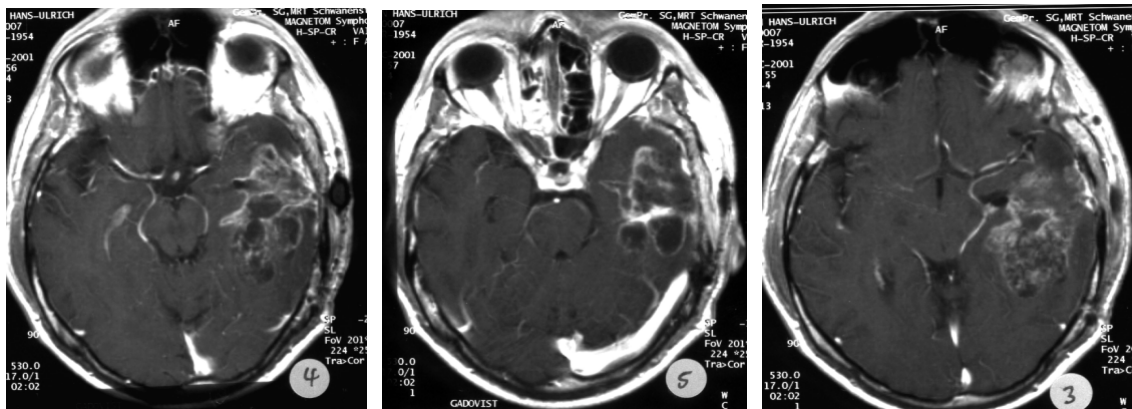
/a. Pretreatment imaging with MRI, -T1 12.12.2001
